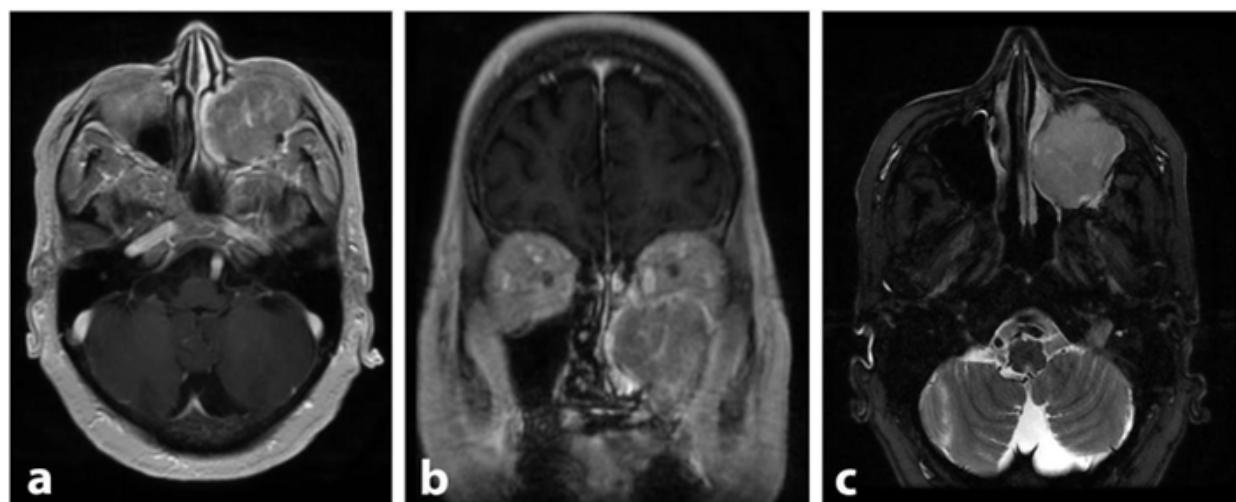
Preoperative magnetic resonance imaging. a) Axial T1-weighted magnetic resonance imaging with gadolinium, showing an infiltrative mass within the left maxillary sinus, protruding into the nasal cavity. b) Coronal T1-weighted magnetic resonance imaging with gadolinium, showing the infiltrative mass within the left maxillary sinus, protruding into the nasal cavity and left orbit. c) Axial T2-weighted magnetic resonance imaging, confirming the extra-axial aspect of the mass within the left maxillary sinus.
